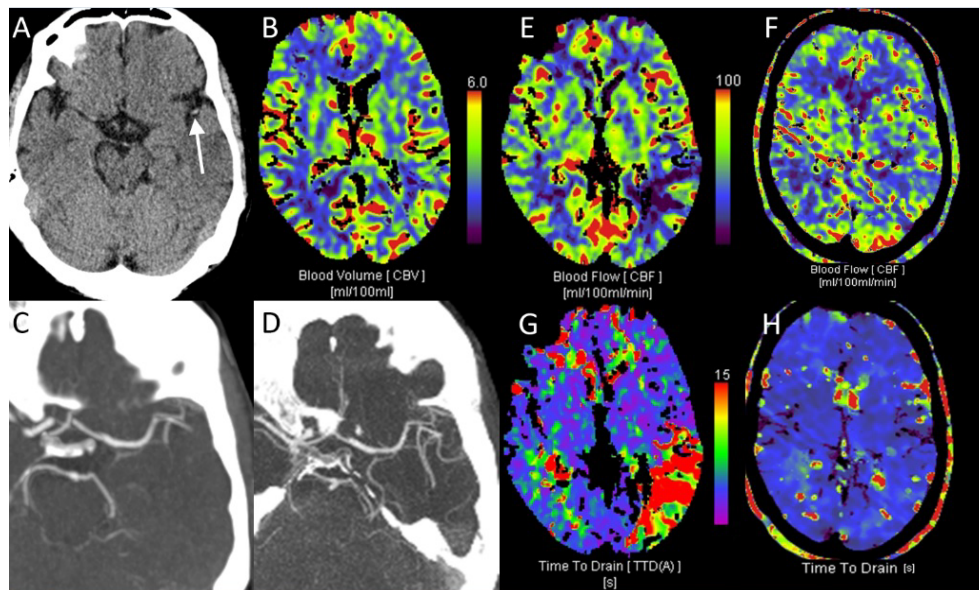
(1A). MDCT displayed a dense artery sign in the left MCA. Other early signs of infarction or intracranial haemorrhage could not be detected. (1B). MDCTP CBV map showed a slightly reduced blood volume in the left temporooccipital region as opposed to the right hemisphere. (1C). MDCTA showed the abrupt stop of contrast agent in the left proximal temporal M2 segment. (1D). In FDCTA the left proximal M2-segment is patent. (1E). CBF maps acquired via MDCTP show a reduced blood flow in the left temporooccipital region leading to a CBF-ASPECTS Score of 7. (1F). Corresponding to the improvement of the patient's clinical symptoms, the CBF map acquired via FDCTP showed a normalized CBF. (1G). Increased time to drain in the initially acquired TTD map in MDCTP in the left temporooccipital region. (1H). Normalized TTD in the FDCTP after the patient's symptoms improved.
